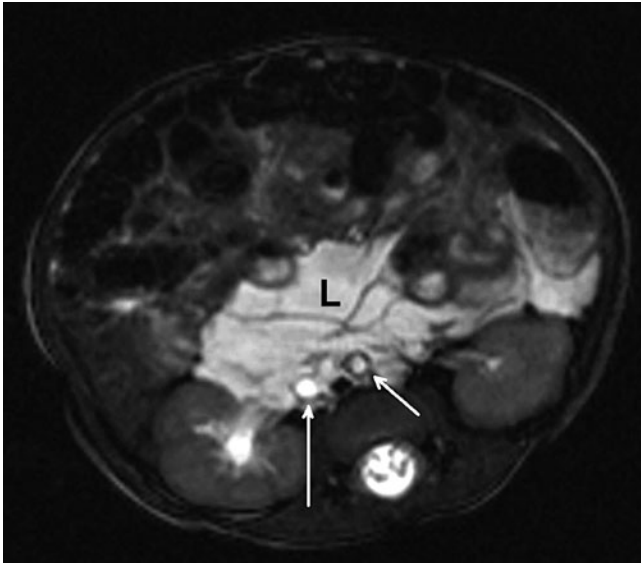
Transverse T2-weighted magnetic resonance image. An infant with a retroperitoneal cystic lymphatic malformation (L). Aorta and inferior caval vein (ICV) are encased by the cysts (arrows)
